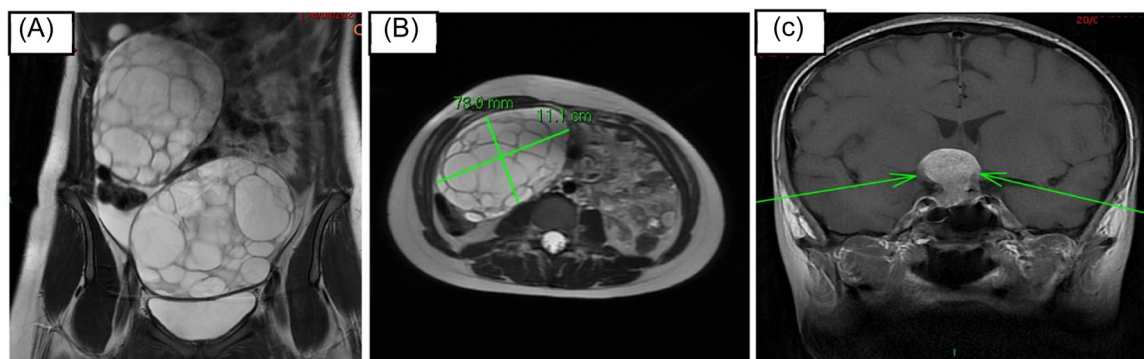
(A, B) Magnetic resonance imaging (MRI) pelvis, coronal and axial view: Bilateral circumscribed thin walled multiseptated cystic masses arising from the pelvis and extending into the abdomen. The right measures $13 \times 11 \times 7.3$ cm, the left $13 \times 12 \times 8$ cm. (C) Coronal view MRI pituitary: a 36×18 mm mass arising from the pituitary, with significant suprasellar extension. [Color figure can be viewed at wileyonlinelibrary.com]
